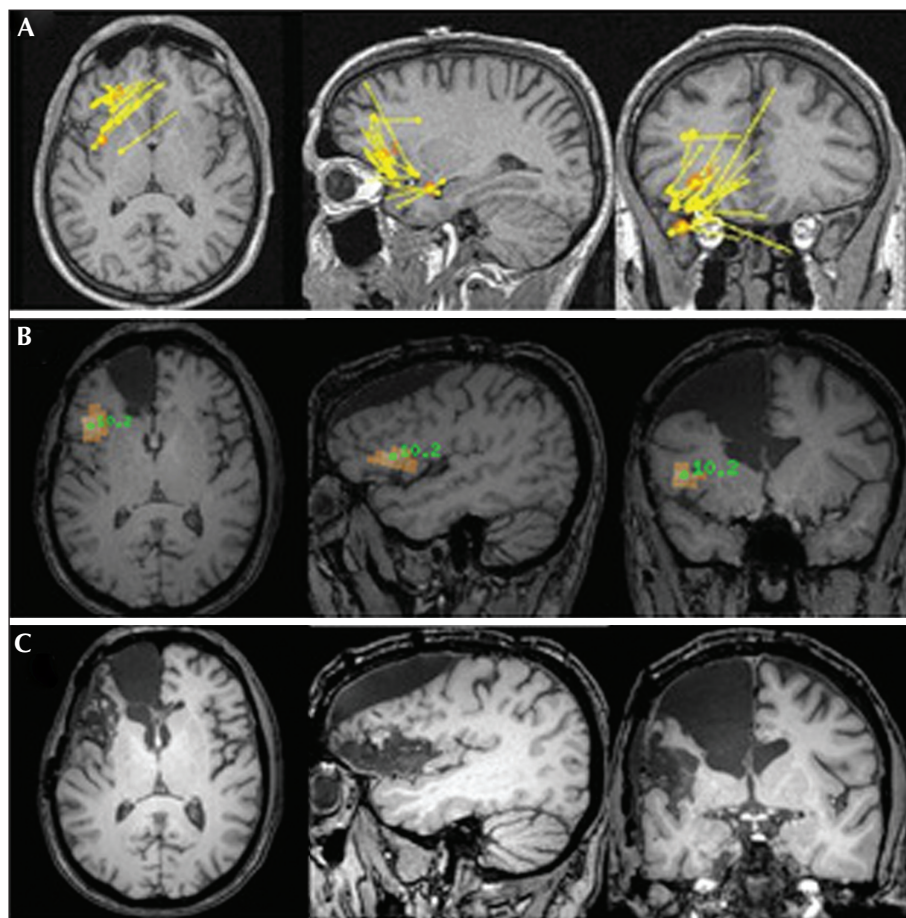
(A) Magnetoencephalography study (acquired prior to first surgery but analysed only after) showing clustered sources using the equivalent current dipole model over the anterior insula, posterior orbitofrontal cortex, and frontal operculum. (B) Magnetoencephalography study (performed after the first surgery) showing probable source of high-frequency gamma oscillations in the anterior insula using the Beamformer model. (C) MRI showing the location and extent of the first surgery over the anterior frontal region (arrow) and the second surgery at the junction of the frontal operculum, anterior insula, and posterior orbitofrontal cortex (triangle).
